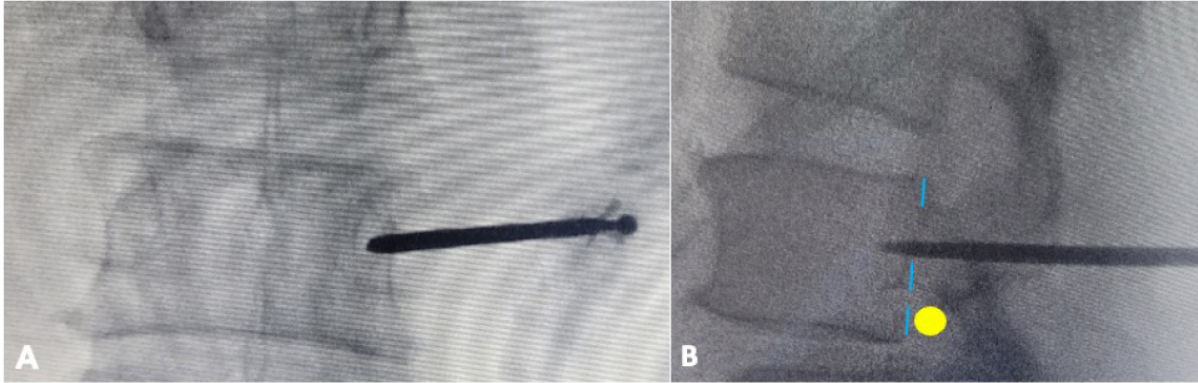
(A) AP X-ray showing that the Jamshidi needle tip has reached near the medial border of the pedicle. (B) Lateral X-ray showing that the needle tip has crossed the posterior vertebral cortex (dotted blue lines), thus ensuring that the needle has not violated the spinal canal. Lateral X-ray also shows needle parallel to superior endplate of the vertebra. The inferior wall of the pedicle is not violated, since the exiting nerve root (yellow circle) is in close proximity to the inferior wall of the pedicle.
